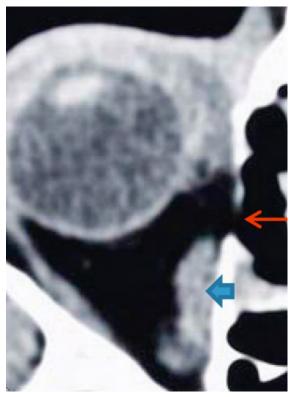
Postoperative axial CT-scan of the left side showing destruction of the lamina papyracea (red arrow) and also complete transsection of the medial rectus muscle in the course of routine paranasal sinus surgery (blue arrow: retracted stump of the muscle).
